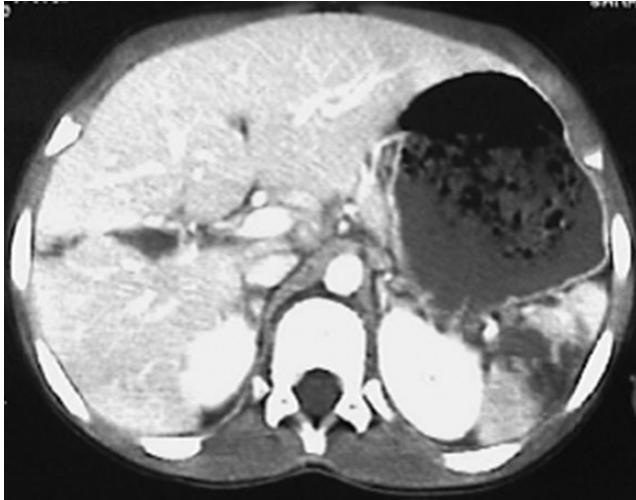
Abdominal contrast CT scan of a 7-year-old boy with a liver rupture grade II and an associated splenic rupture.
